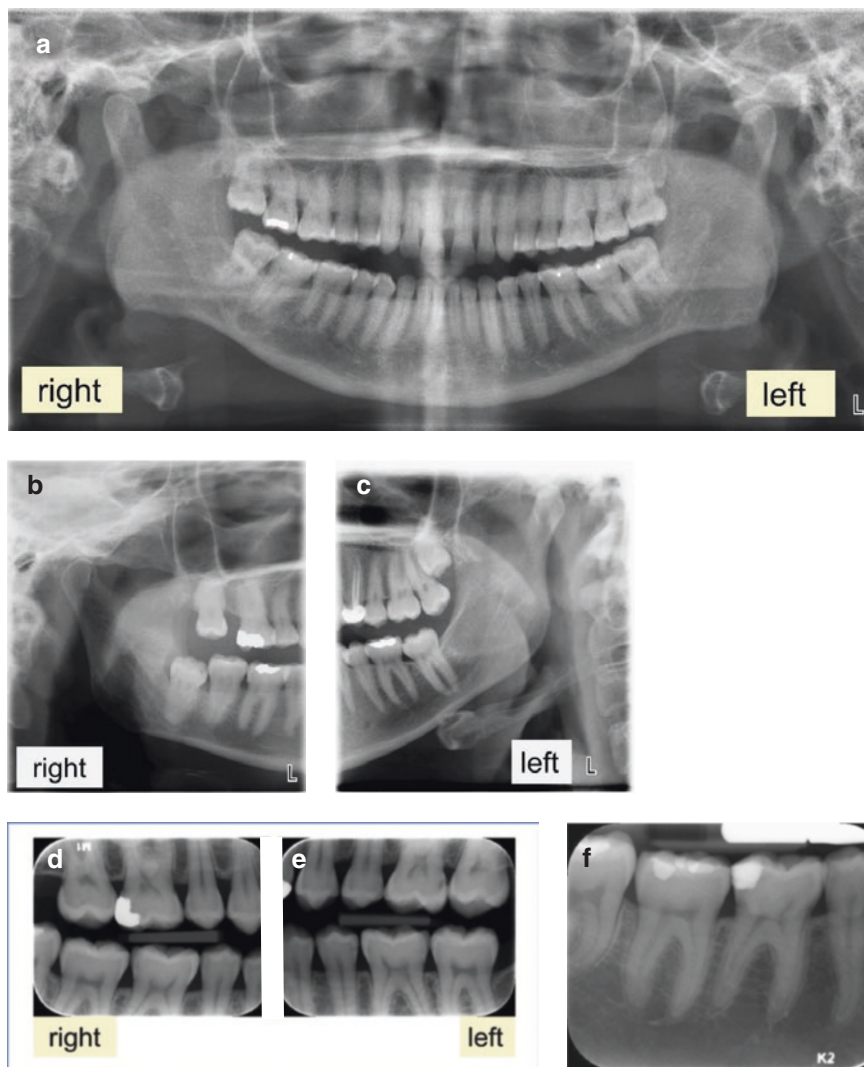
Right and left orientation in conventional dental radiography:
